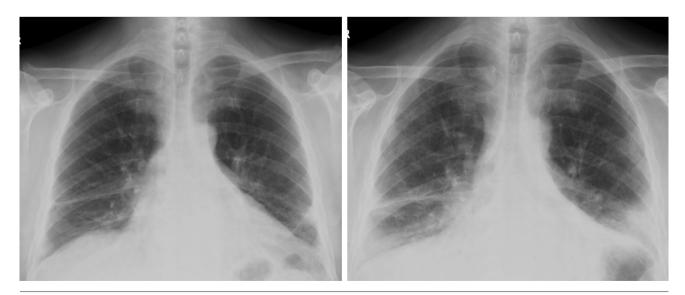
Chest X-ray before (left) and after COVID-19 infection (right). After COVID-19, new areas of bilateral decreased parenchyma transparency and consolidation are found.
